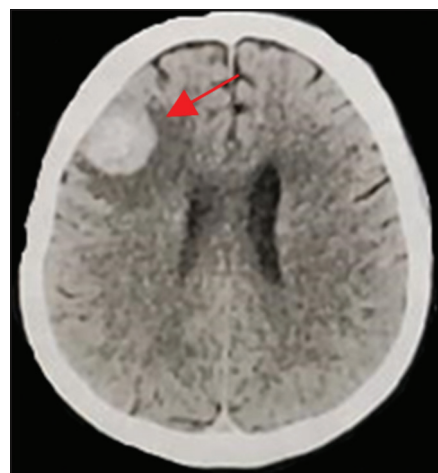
Computed tomography scan at the end of 2 weeks after operation showing a new lesion in the right frontal lobe (red arrow).
